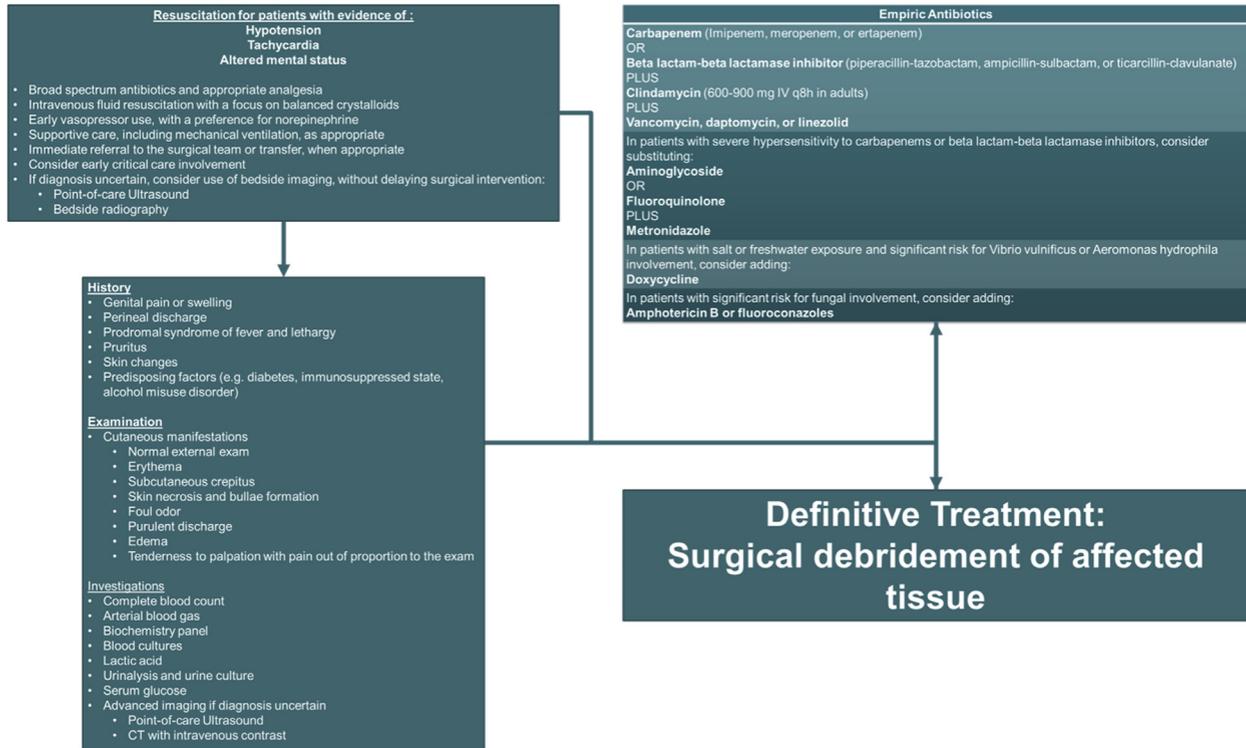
Management algorithm for patients with Fournier gangrene. CT = computed tomography.
